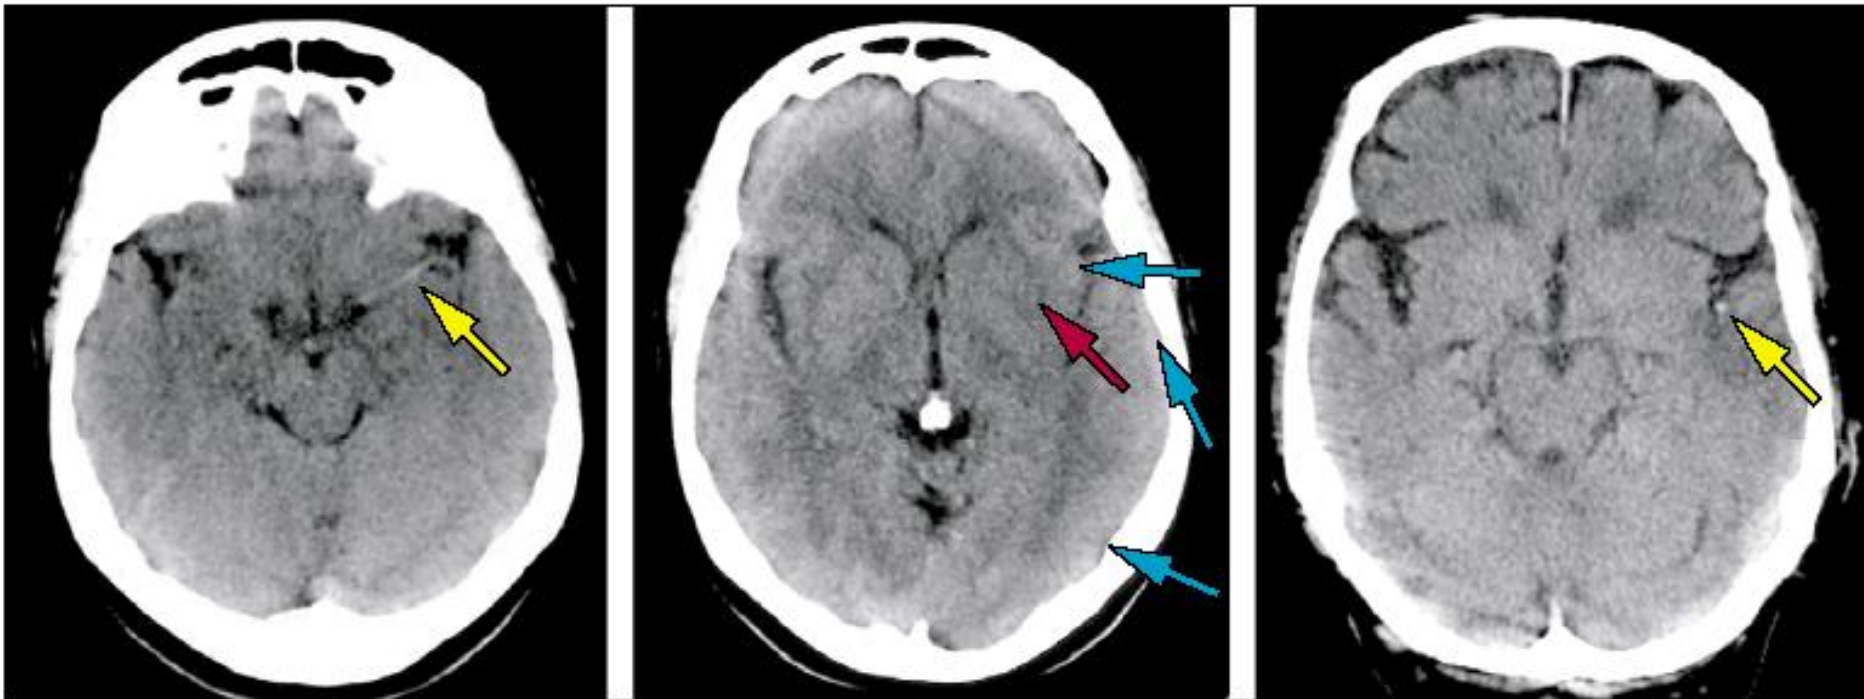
Early CT signs in acute MCA stroke
